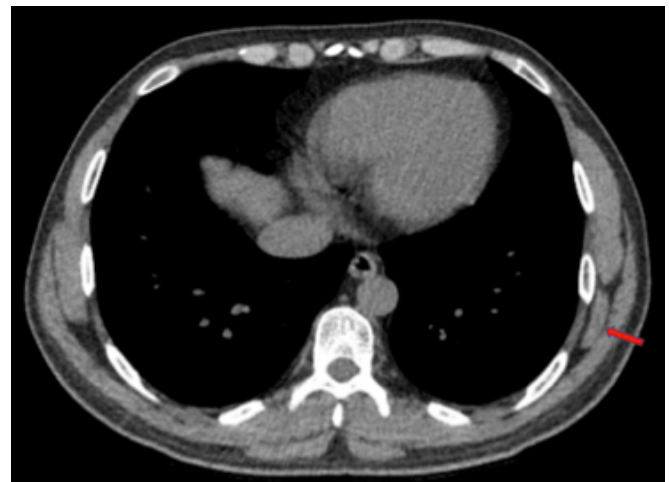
In the axial CT image, a 66-year-old female patient with left unilateral ED (red arrow).
